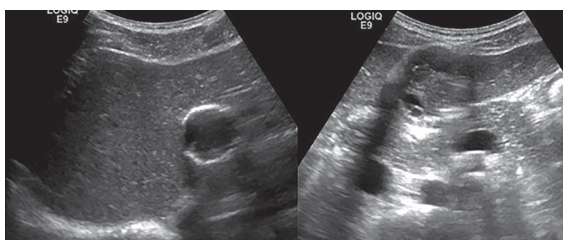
Sonograms focused on the hepatic parenchyma shows two different locations of the hydatid cyst in the left liver.
